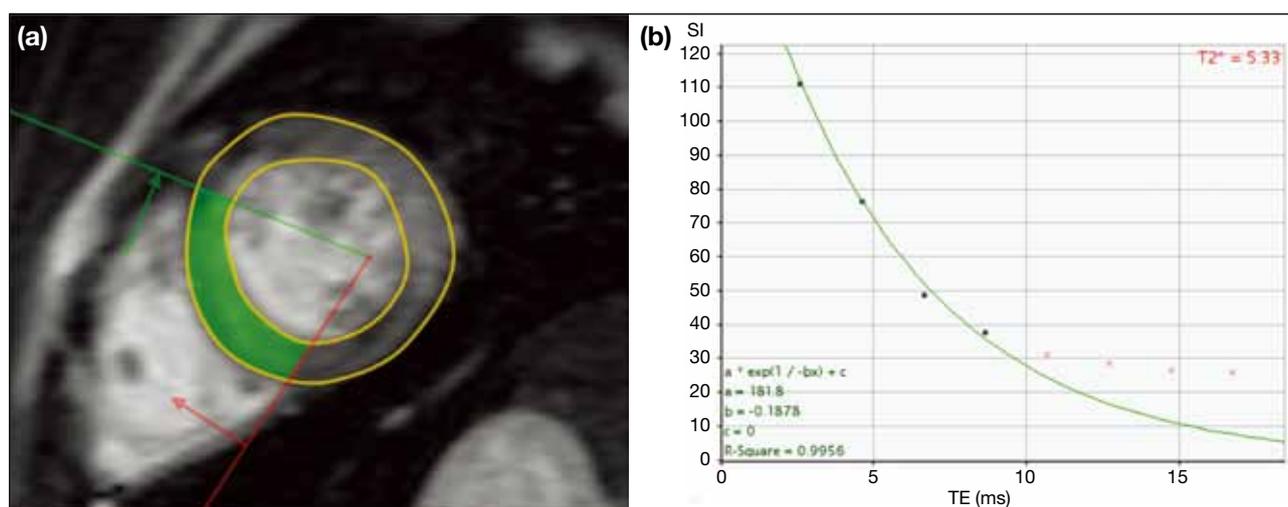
Magnetic resonance imaging assessment of myocardium T2* value. (a) Transmural region of interest is drawn in the ventricular septum (highlighted in green). Caution has been taken to avoid potential susceptibility artefacts from the cardiac veins and air in the lung. (b) Data analysis using thalassaemia tools (CMR tools, Cardiovascular Imaging Solutions, London, UK): the signal intensity (TE) is plotted against multiple TE values (2.6, 4.62, 6.64, 8.66, 10.68, 12.7, 14.72, 16.47 ms). The exponential signal decay curve is then constructed. T2* value is calculated automatically by the preset formula. A T2* value of less than 10 ms indicates severe iron overload in the heart.
